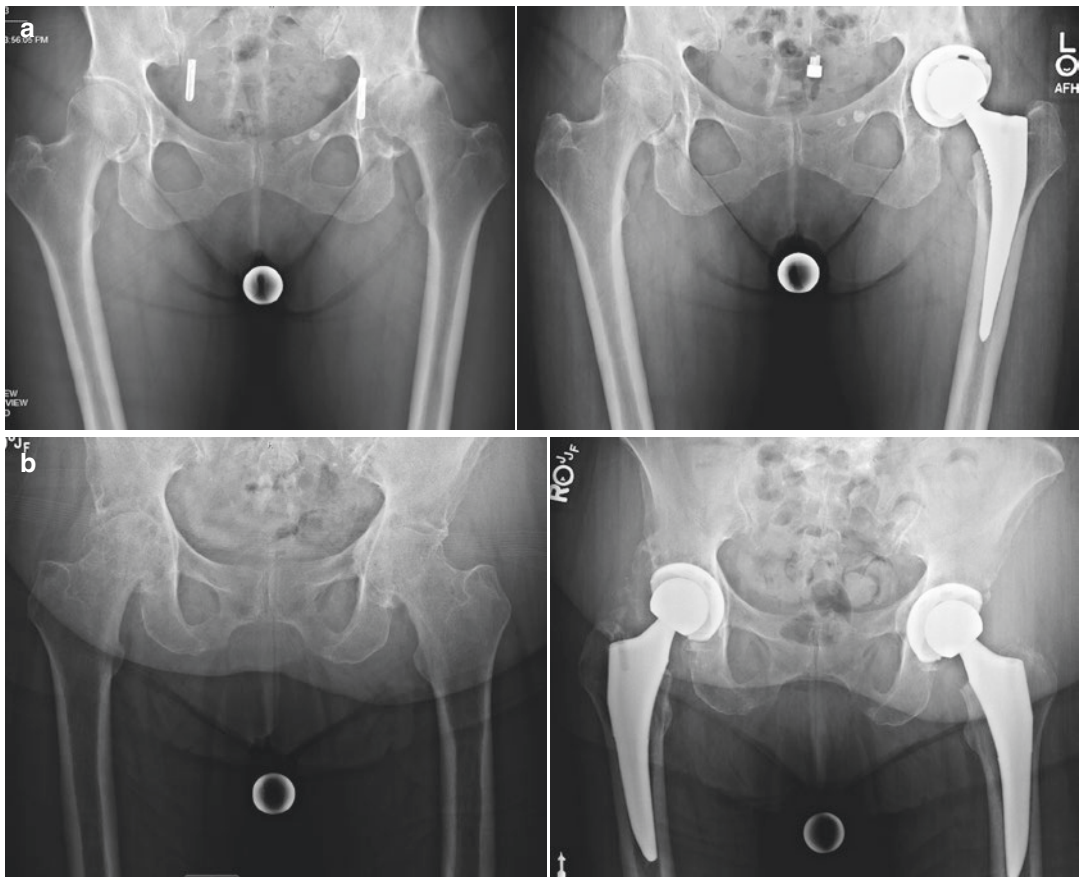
Pre-operative and post-operative films of patients with different bone morphology. (a) Pre-operative and post-operative radiographs of a left THR in Dorr
